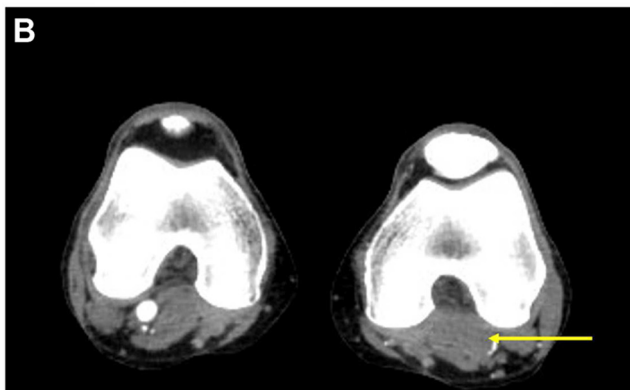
Computed tomographic angiogram of a 63-year-old man with left popliteal aneurysm thrombosis after vaccination against SARS-CoV-2. (A) Anteroposterior reconstruction of the femoropopliteal segments. Note the thrombosis of the left popliteal artery (arrow). (B) Cross-sectional view at the level of the knee. Note the thrombosis of the left popliteal aneurysm measuring 1.9 cm in diameter (arrow).
